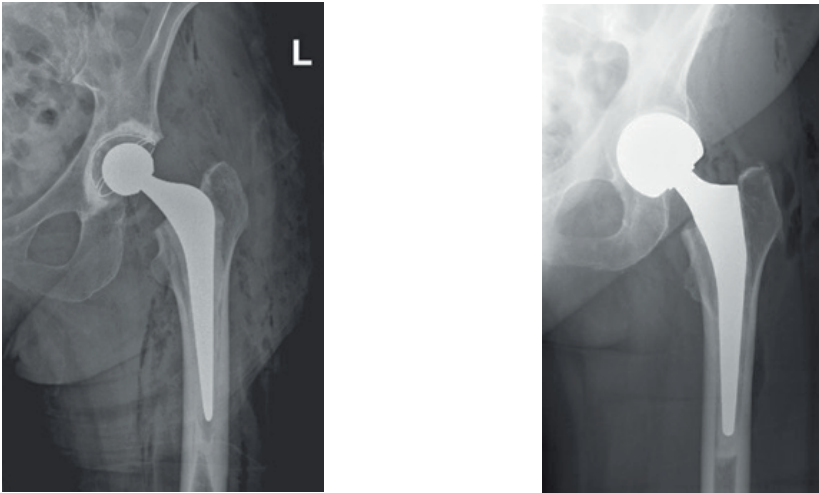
Radiograph of a total hip arthroplasty with the use both a femoral and an acetabular component (left) and a hemiarthroplasty with only a femoral component (right).
